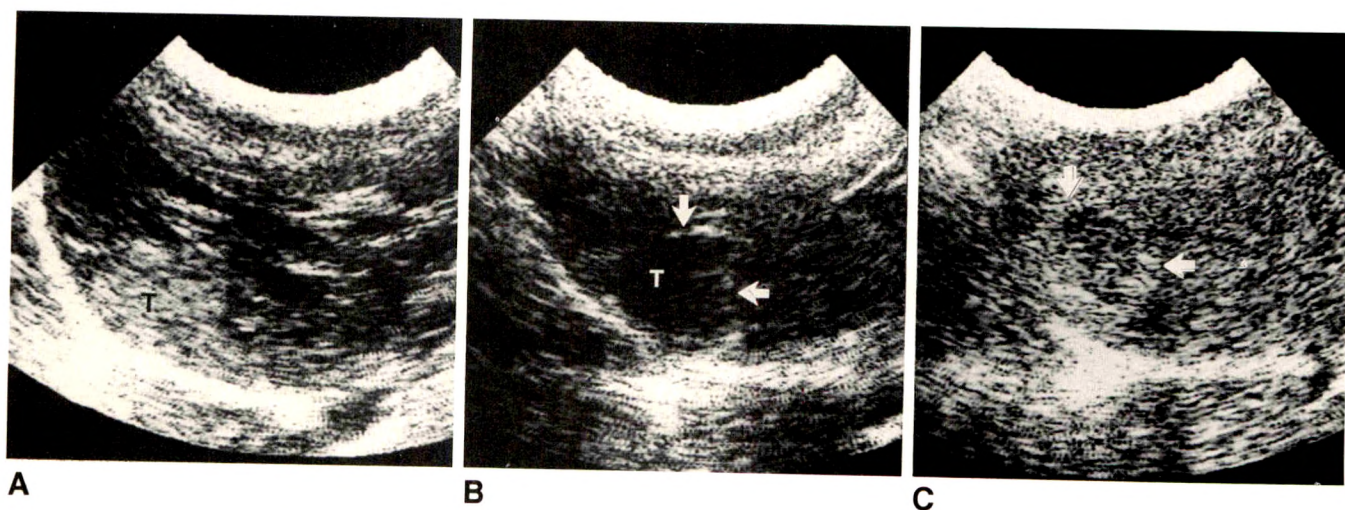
Longitudinal sonograms of liver at level of Vx2 tumor of rabbit in Fig. 2.
